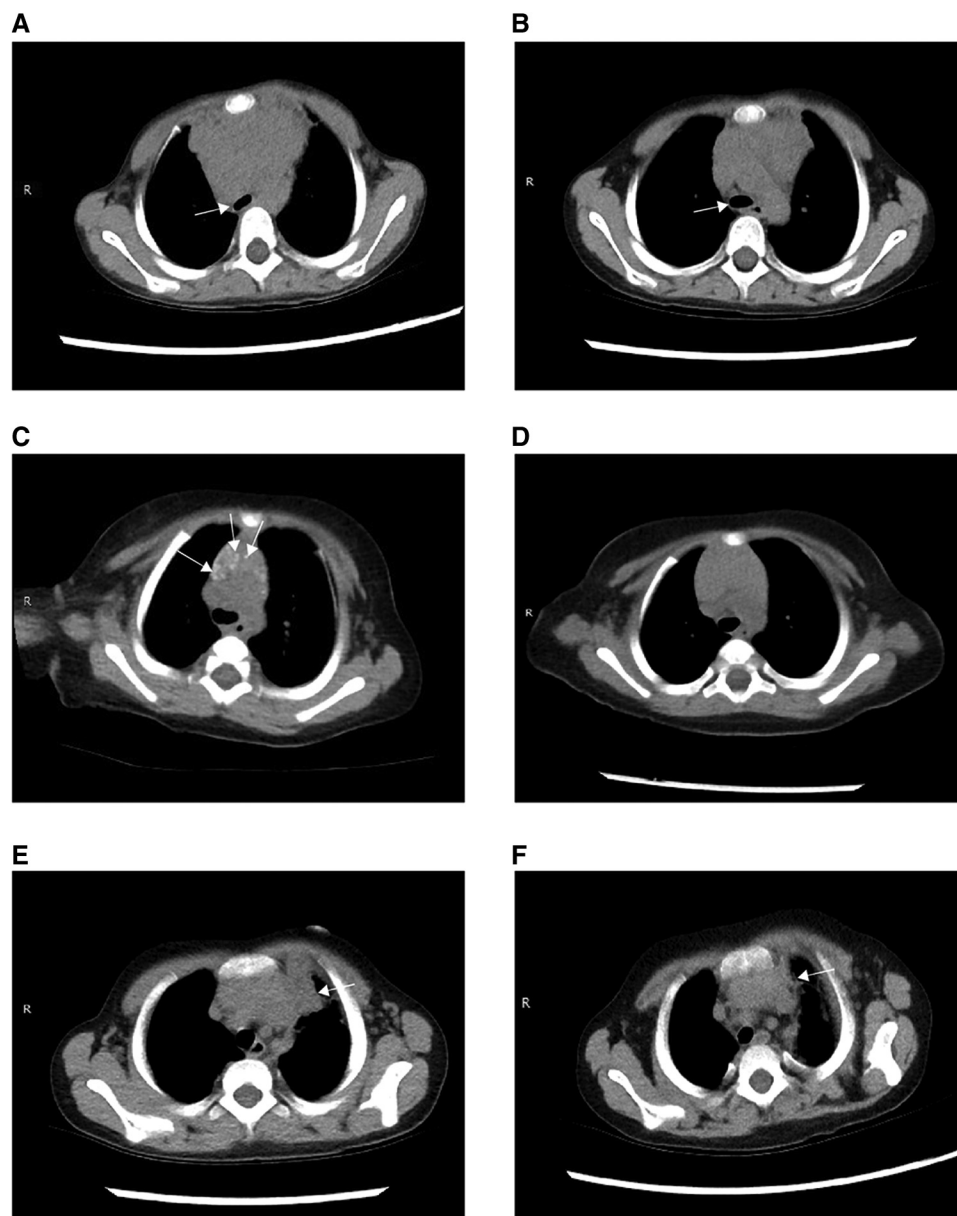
Imaging presentation of thymus on thoracic CT of patients with LCH with thymic involvement. A, Presence of an enlarged mass in the anterior mediastinum and tracheal compression (*arrow*) in patient P9. B, Reduction of thymus size and tracheal compression (*arrow*) after 6 weeks of induction treatment in patient P9. C, Presence of calcifications in the thymus of patient P17 (*arrows*). D, Reduced calcifications in the thymus of patient P17 after 3 months of dabrafenib administration in patient P17. E, Presence of the thickening pleura diffusely extends to the anterior mediastinum with unclear boundaries in patient P18 (*arrow*). F, Reduction of thickening pleura after six week of induction treatment in patient P18 (*arrow*).
